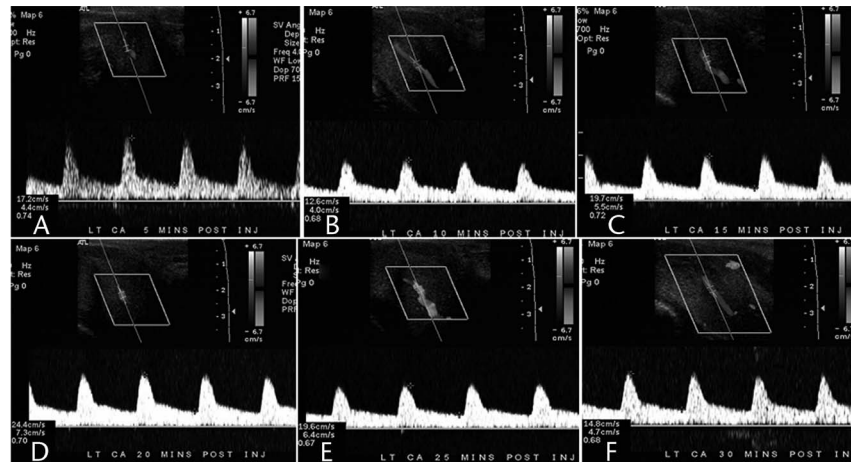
A 57-year-old man presents with erectile dysfunction. A–F, Sagittal spectral Doppler images from 5 to 30 minutes after prostaglandin injection show a maximum velocity within the cavernosal artery of 24 cm/s at 20 minutes, which is consistent with arterial inflow disease. In addition, an increased end-diastolic velocity greater than 5 cm/s is present, indicating accompanying venous leak.
